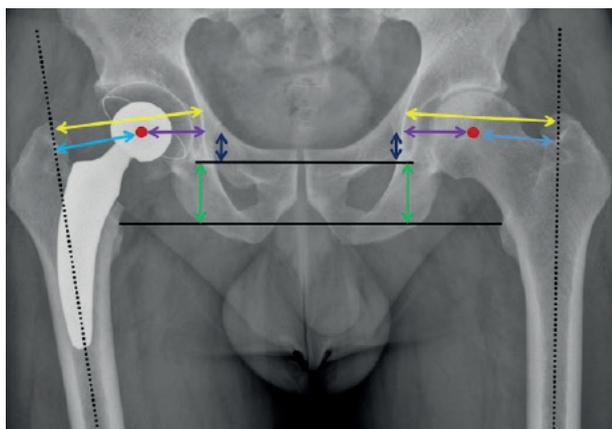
Radiologic parameters measured on a standardized anteroposterior radiograph of the pelvis. The contralateral native hip was used as reference. The center of rotation is marked with a red circle. The anatomical axis of the femur is shown with a dotted black line. The more distal edge of the teardrops and the more proximal points of the lesser trochanter are connected with black lines (inter-teardrop and inter-trochanter lines, respectively). The leg length was defined as the distance between the inter-teardrop and inter-trochanter line (green arrow). The femoral offset is shown with a light blue arrow as the distance between the long axis of the femur and the center of the femoral head, whereas the acetabular offset with a purple arrow as the distance between the true floor of the acetabulum and the center of the femoral head. The vertical center of rotation is shown with a blue arrow as the distance between the inter-teardrop line and the center of the femoral head.
